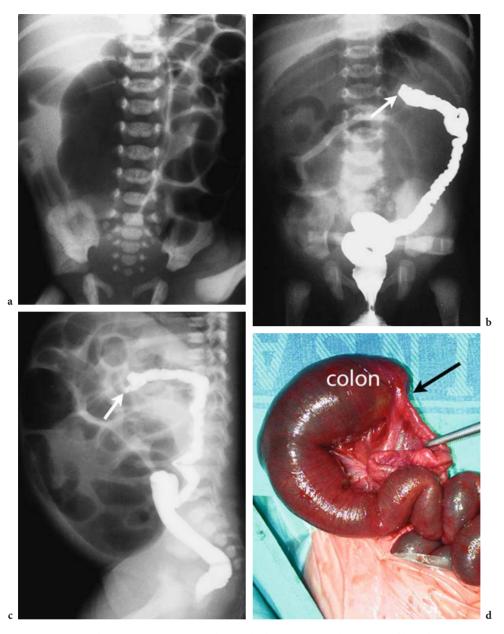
Colon atresia. a Supine radiograph shows gaseous distension of bowel. b,c Contrast enema, anteroposterior and lateral views show abnormally small colon (microcolon) with complete obstruction to retrograde flow of contrast material proximal to the middle transverse portion of colon. d Photograph at operation shows a distended colon up to the site of the atresia (*arrow*) and a microcolon distal to it
